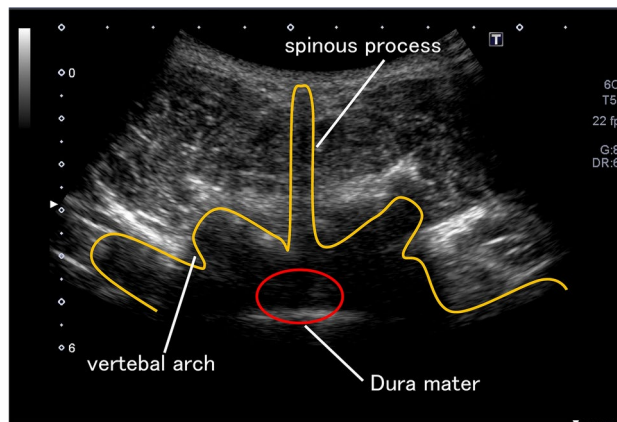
Axial images of the lumbar spine and dural mater observed with ultrasound. L4-L5 dura mater.
